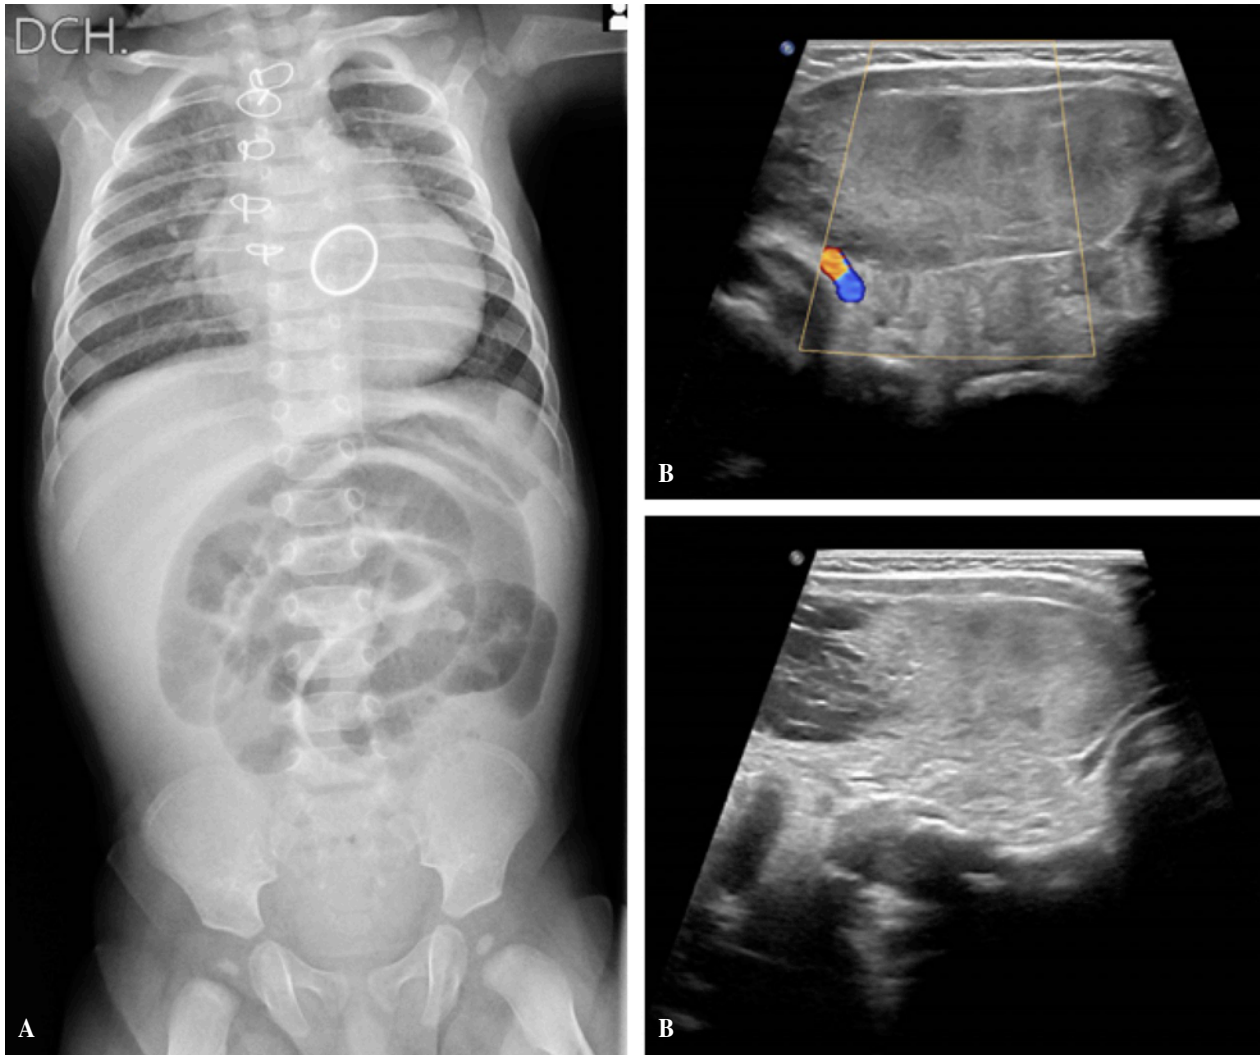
A) Abdominal X-ray: Dilatation of proximal small bowel loops up to 2-3 cm in diameter, with no colonic air. B) Ultrasonography: Aperistaltic loop at the hypogastrium, dilated up to 2 cm, partitioned inside, with echogenic content and signs of intestinal suffering.
